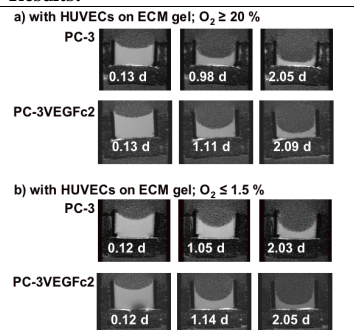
T₁-weighted ¹H MR images of PC-3 and PC-3VEGFc2 cells, both combined with HUVECs on the ECM gel demonstrating
